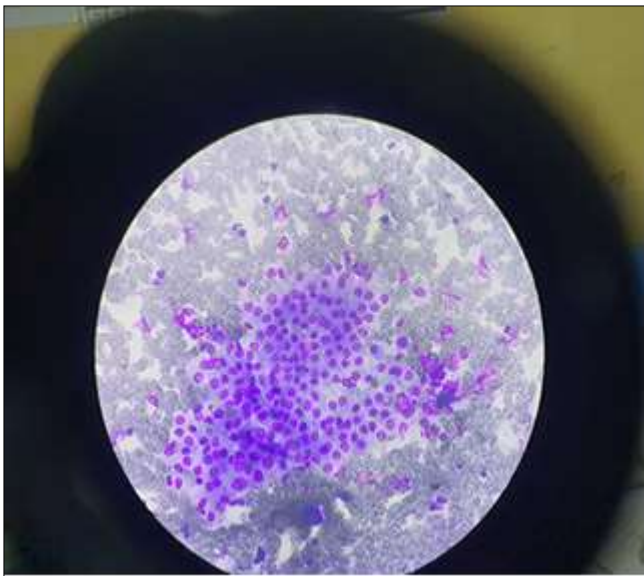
FNA of the nodule was consistent with multinodular goitre (Bethesda II category) As per TI-RADS guidelines, sonography features are evaluated in five categories:
